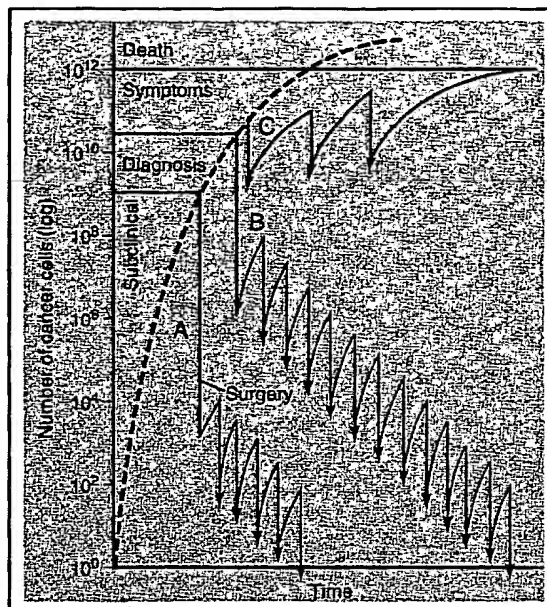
■ The relationship of tumor growth and tumor burden to treatment strategies and outcome with systemic chemotherapy. Human tumors grow in accord with the Gompertz curve (dashed line), with a decreasing doubling time as tumor burden increases. Treatment interventions relate to tumor type and extent of disease. A, Surgery followed by pulse courses of adjuvant chemotherapy. B, Systemic chemotherapy for stage III Hodgkin's disease. C, Palliative chemotherapy for advanced non-small cell cancer. In A, combined modality has curative potential with the addition of chemotherapy after surgery. Cure is also possible in B with prolonged administration of combination chemotherapy. In C, the patient's tumor burden is too great and the potency of the drugs for this specific form of cancer is inadequate because of development of drug resistance. (Modified from Salmon SE, Sartorelli AC: Cancer chemotherapy. In Katzung BG [ed]: Basic and Clinical Pharmacology, 4th ed. Norwalk, CT, Appleton & Lange, 1989, p 685.)
